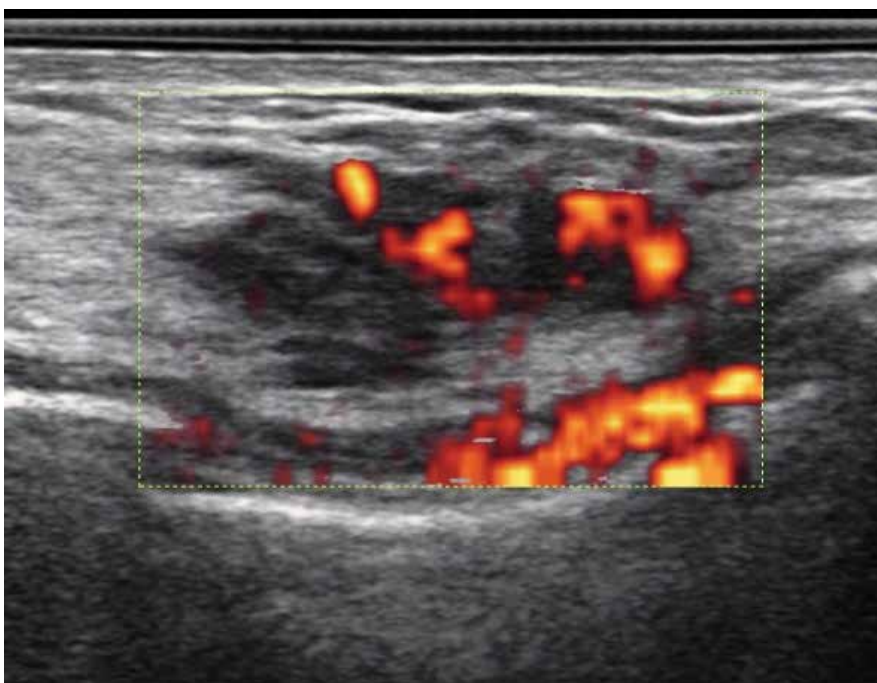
DCIS: Horizontal growing pattern of a DCIS with microinvasion, clear vascularization in color Doppler
